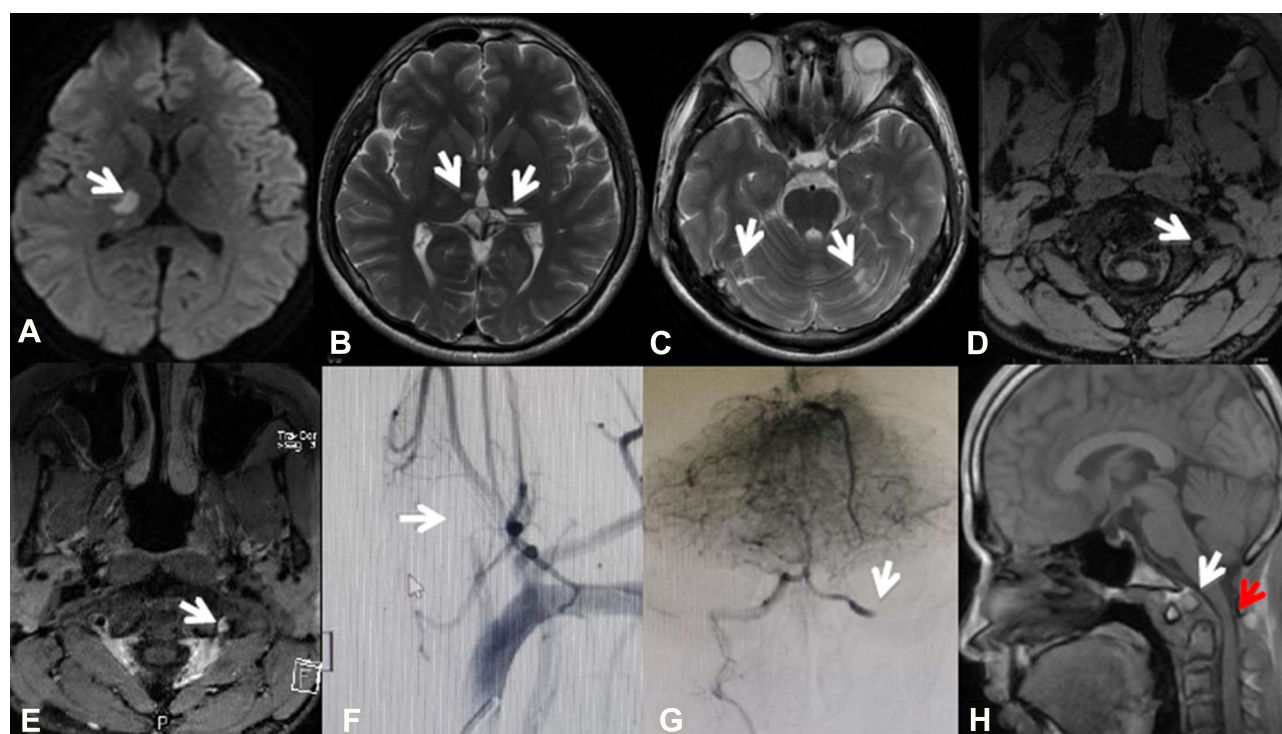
(A–C) Cranial MRI showing an acute infarct in the right thalamus and multiple old infarcts in the left cerebellar hemisphere and bilateral thalamus (white arrow); (D, E) HR MRI showing dissection (white arrow) in the atlantoaxial segment of the left VA; (F, G) DSA demonstrating distal occlusion of the left VA in atlantoaxial segment (white arrow); (H) sagittal cranial MRI showing atlantoaxial spinal canal stenosis (red arrow) and os odontoideum (white arrow).
